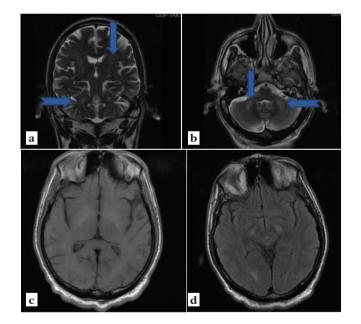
Coronal and axial T2 weighted images (a, b) show symmetric bilateral hyperintensities in middle cerebellar peduncles. On axial T1 weighted image (c), hyperintensities in globus pallidus and putamen. Axial FLAIR image (d), shows bilateral hyperintensities on cerebral peduncles
